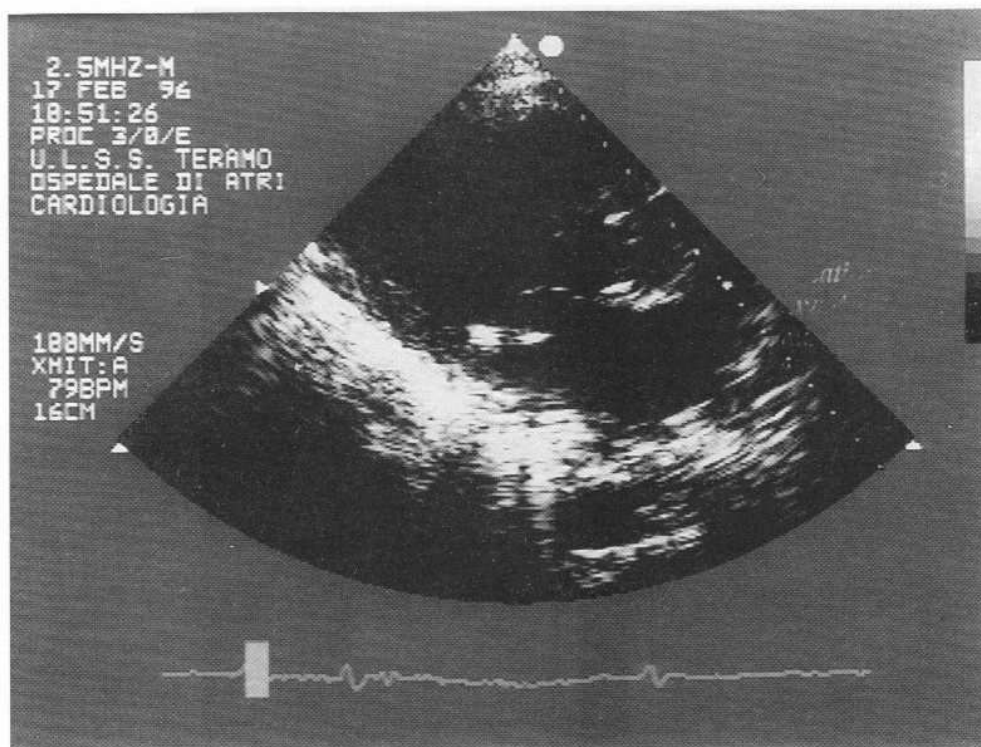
Echocardiography at admission: vegetation can be noted on mitral valve and subvalvular space of semilunar valves.
